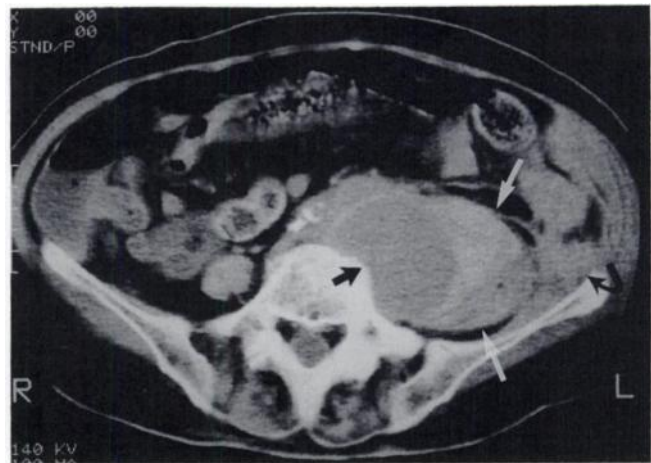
A CT scan at the level of iliac arteries confirms the presence of a large left iliac aneurysm (straight black arrow) with alternate high and low attenuating areas at the periphery representing thrombus formation (white arrows). Perianeurysmal hemorrhage and leak is seen lateral to the aneurysm and anterior to the lateral aspect of iliac bone (curved black arrow).
